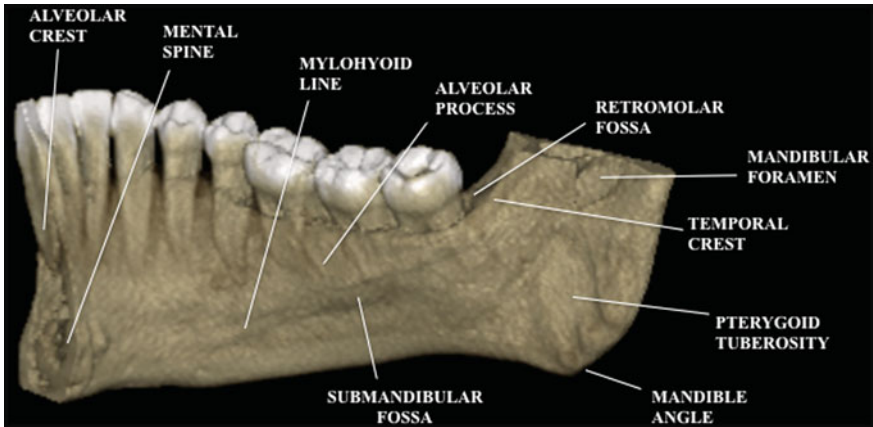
Mandible, CBCT-3D reconstruction of right hemiarch: medial surface
